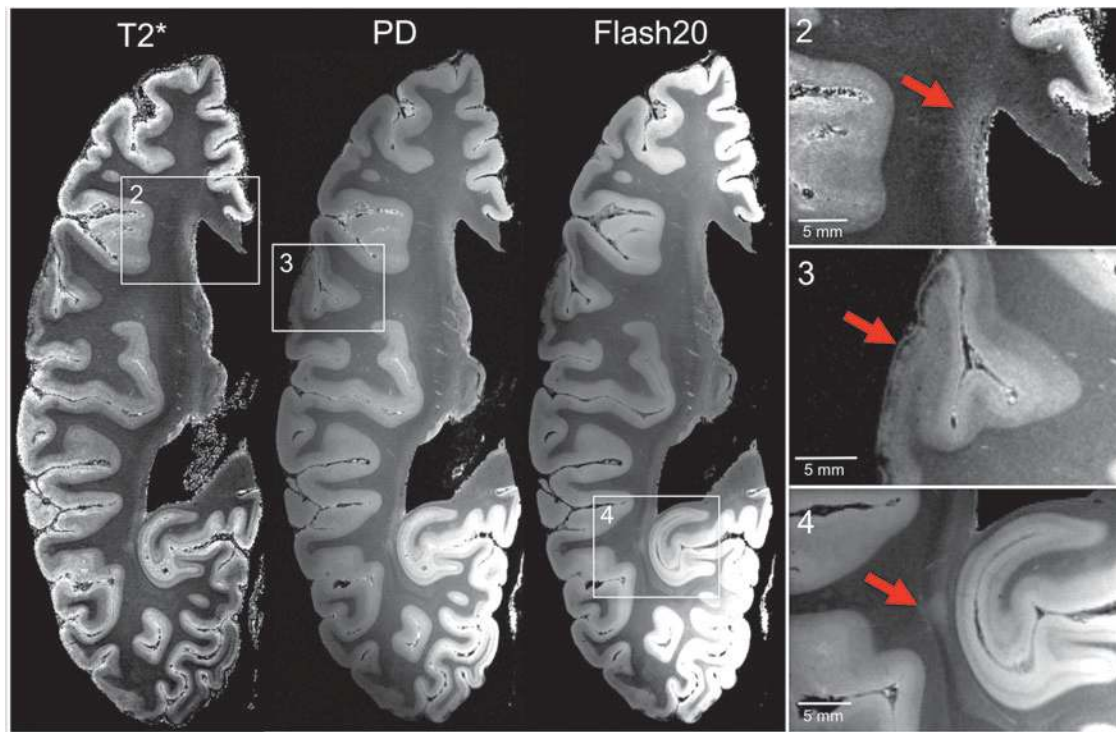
Ex vivo* 7 Tesla magnetic resonance imaging (MRI) reveals focal lesions not detected by *in vivo* 3 Tesla MRI. Axial T2*, proton density (PD), and flash20 images synthesized from the multi-echo flash sequence are shown at the level of the superior border of the thalamus. These three datasets reveal two lesions that were not visualized on the *in vivo* MRI dataset (lesions 3 and 4) and confirm the presence of a lesion that was seen *in vivo* (lesion 2). Lesion 2 is a periventricular hyperintensity in the frontal lobe, suggesting leukoaraiosis. Lesion 3 is a curvilinear hypointensity that traverses the superficial layers of cerebral cortex in the frontal operculum, suggesting hemosiderin deposition. Lesion 4 is a punctate hyperintensity in the periventricular white matter of the occipital lobe, consistent with leukoaraiosis or possibly chronic traumatic axonal injury. Zoomed views of each lesion are shown on the inset panels, with red arrows indicating the lesions. Color image is available online at www.liebertpub.com/neu
